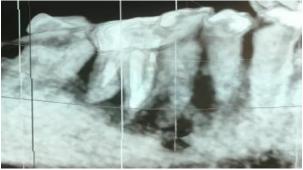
CBCT scan, panoramic reconstruction showing large osteolysis extending from distal aspect of 46 till mesial aspect of 44
